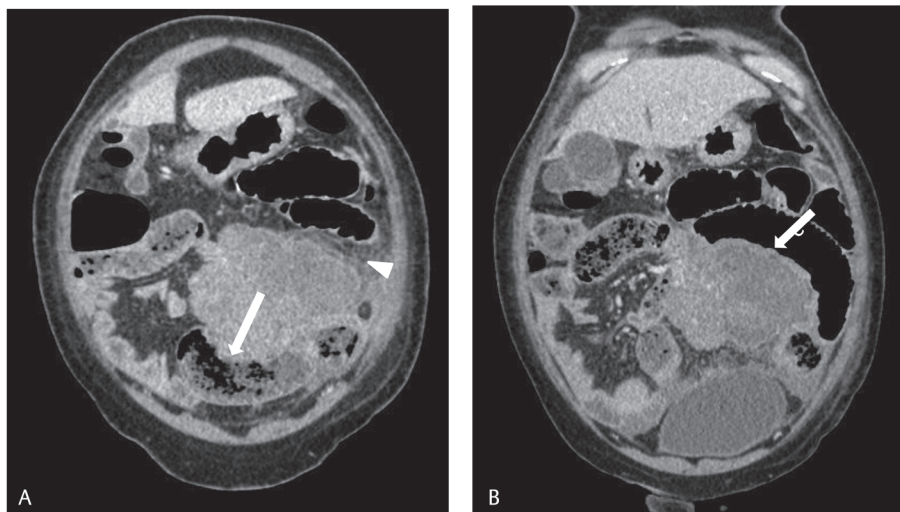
(A, B) Coronal contrast-enhanced CT images of a 44-year-old female with jejunal gastrointestinal stromal tumor (GIST) showing lobulated and irregular contour, invasion into adjacent small bowel loops (white arrows) and omentum (white arrowhead) with coexistent adhesion causing bowel obstruction. High risk. Size: 11.4 cm. Mitotic index (MI) >5/50 HPF.
